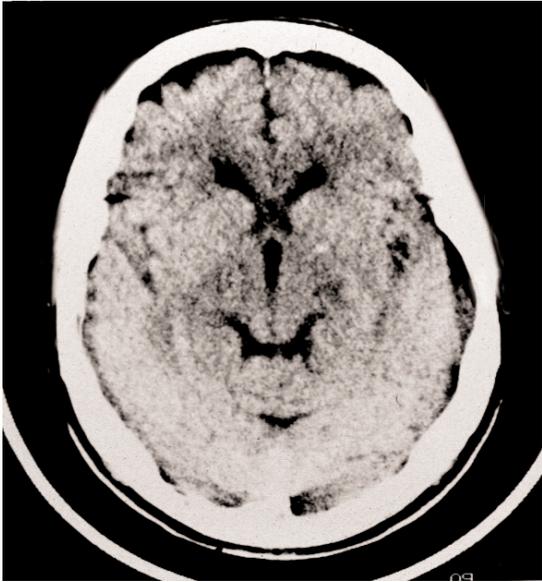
This computed tomography scan shows the lateral geniculate body and its location rostral and lateral to the superior colliculus
